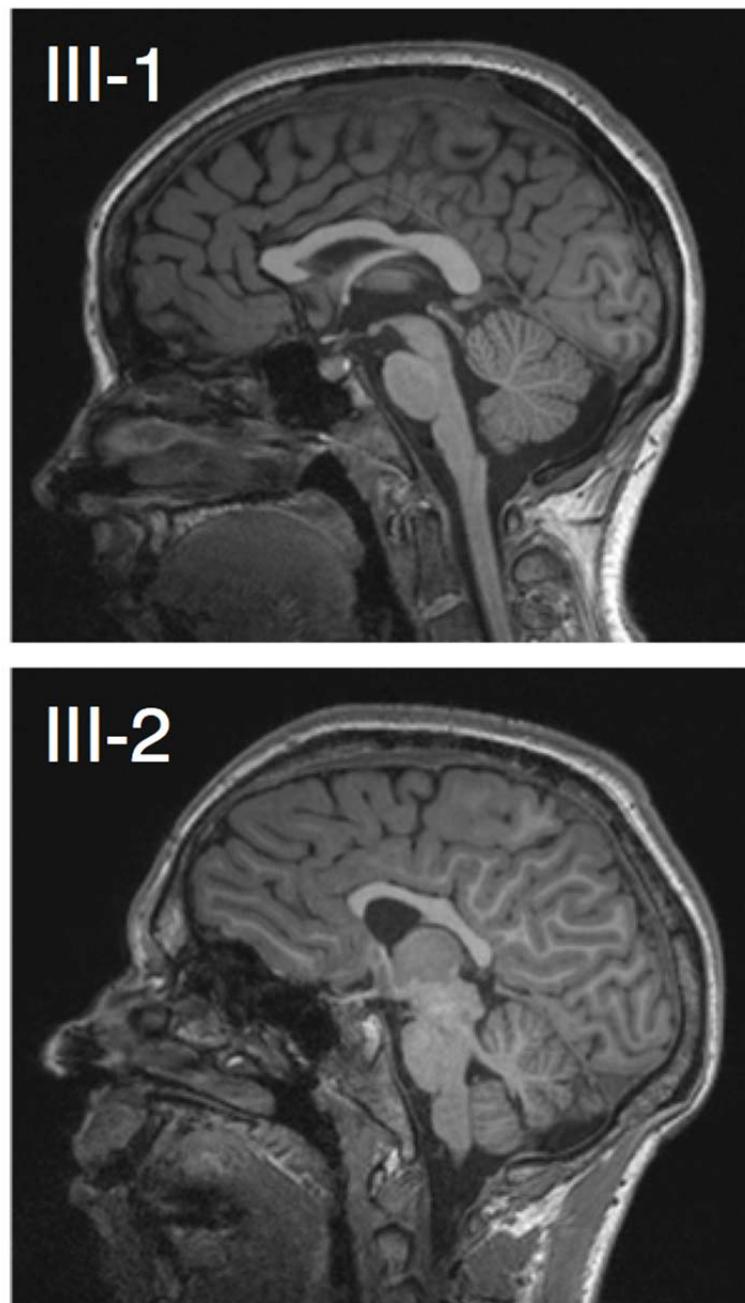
Midsagittal MRI of the daughter (A) and son (B).
